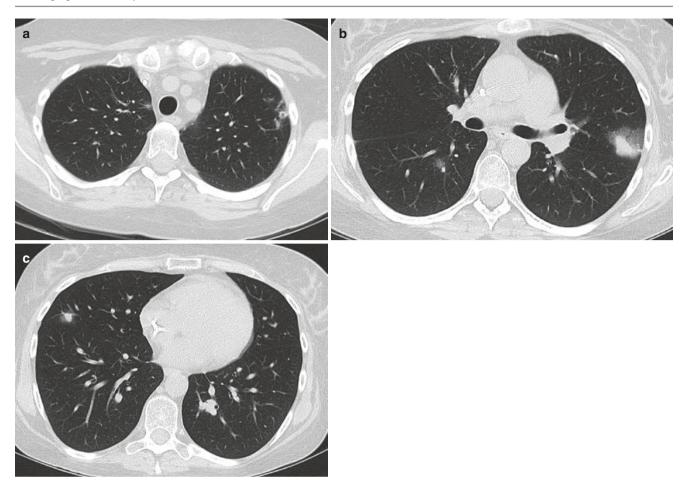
Aspergillosis in a 28-year-old woman with acute lymphoid leukemia. (a-c) HRCT images show lung nodules with surrounding ground-glass attenuation and cavitation
